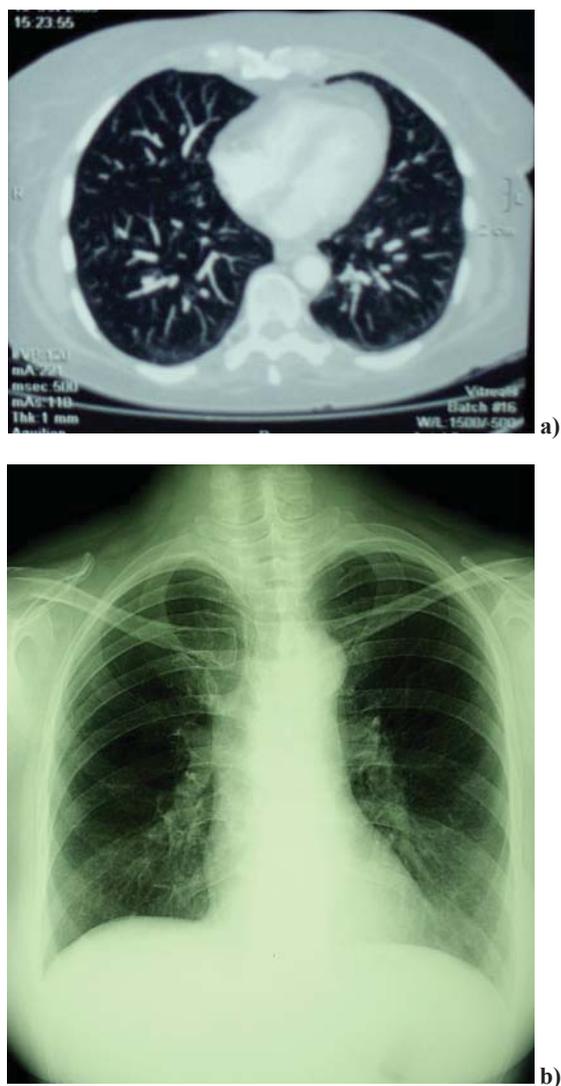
Disappearance of pathological pulmonary changes six months after the treatment shown by multi-slice computerized tomography (a) and chest radiography (b)
